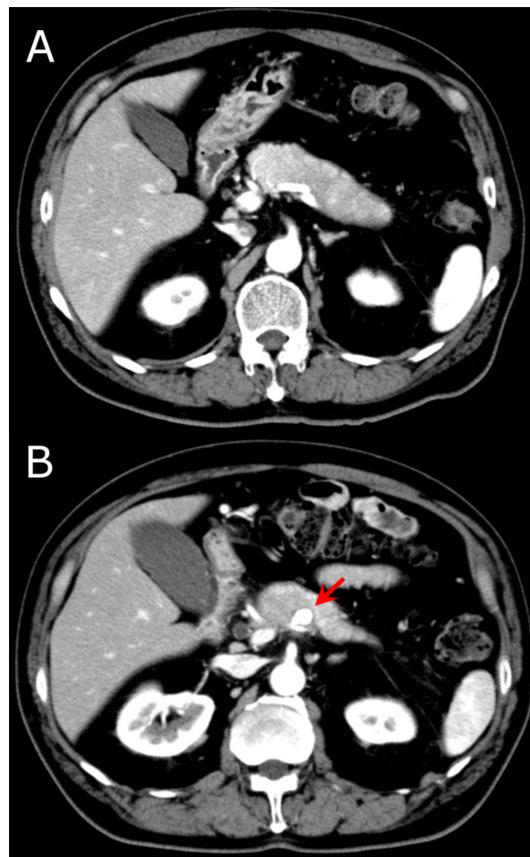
Contrast-enhanced CT on presentation (A) and after 1 year of observation (B) showing diffuse enlargement of the pancreas. A splenic artery pseudoaneurysm (red arrow, 11 mm in diameter) was newly formed at 1-year follow-up (B).
